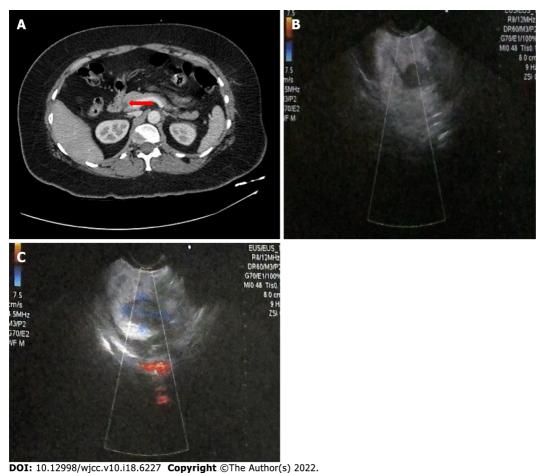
Imaging examinations. A: Computed tomography image for neuroendocrine tumor. The orange arrow indicates a focal asymmetric reinforcement area of 11 mm × 14 mm of 145 HU in the head of the pancreas; B and C: Endoscopic ultrasound images indicating the presence of a homogeneous hypoechoic semioval tumoral lesion in the pancreas, with well-defined borders measuring 2.1 cm x 1.2 cm, in close apposition to the main pancreatic duct and splenomesenteric confluence without evidence of invasion.
